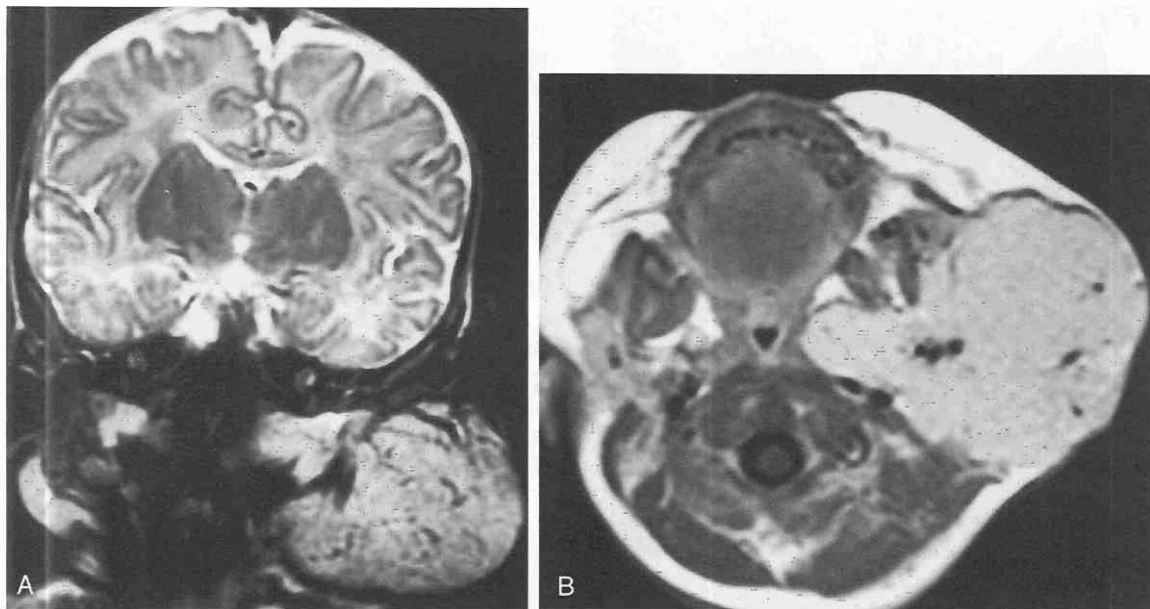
Hemangioma of infancy. A, Coronal fast spin-echo (FSE) MRI scan shows a large mass involving the superficial and deep components of the parotid space. The mass has multiple intralesional flow voids and diffusely hyperintense signal. B, Marked enhancement of the mass with intralesional flow voids is noted on this axial T1-weighted postcontrast MRI scan.
